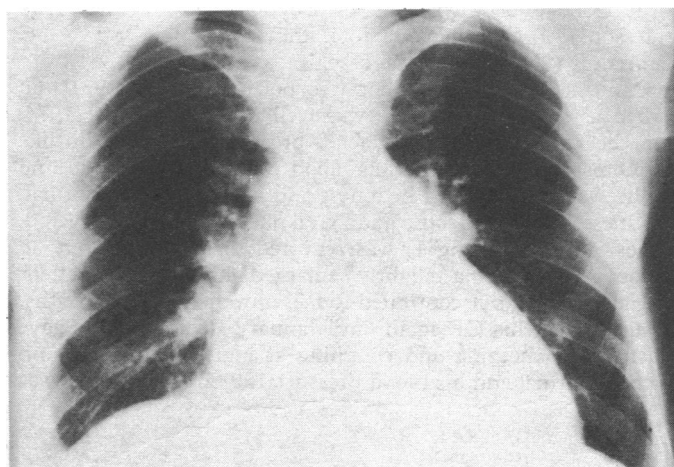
Chest radiograph taken on 7 September 1977, showing greatly enlarged heart.
